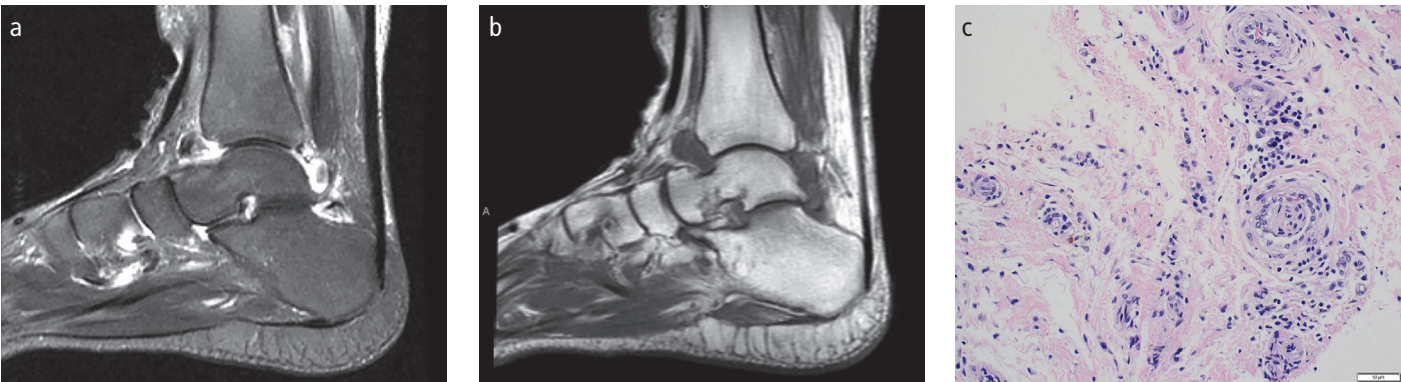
a-c. Sagittal T1-weighted MR images show extensive swelling and erosive changes over the tibiotalar and subtalar joint with intermediate to low T2 suggestive of chronic inflammatory monoarthritis (a, b); Synovial biopsy of the right ankle shows chronic inflammation with few plasma cells, lymphocytes, and some hemosiderin-filled macrophages diagnostic for rheumatoid arthritis (c)
